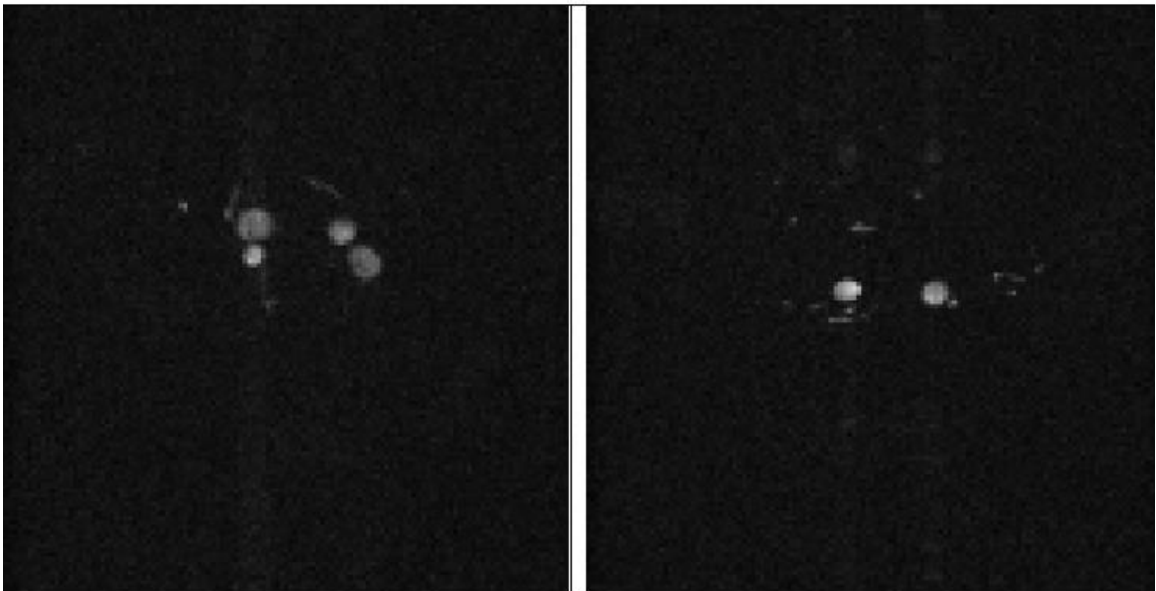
Axial MRI images at $187.5 \times 187.5 \times 500 \mu\text{m}^3$ resolution from above (left) and below (right) the heart. Images are shown after averaging across all diastolic images but without interpolation or smoothing.
